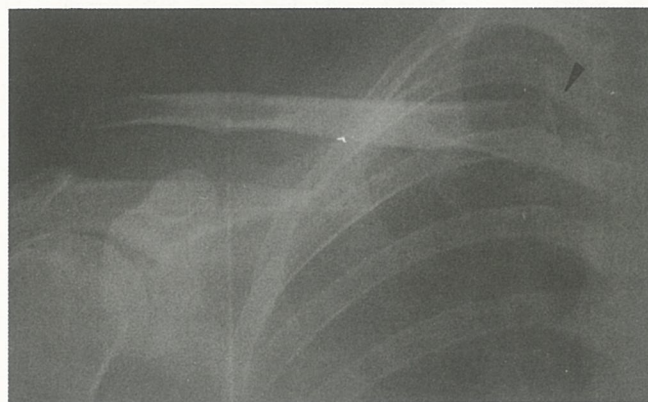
Anteroposterior radiograph of the injured right clavicle shows anterior dislocation of the sternoclavicular joint (arrow) and dislocation of the acromioclavicular joint.
